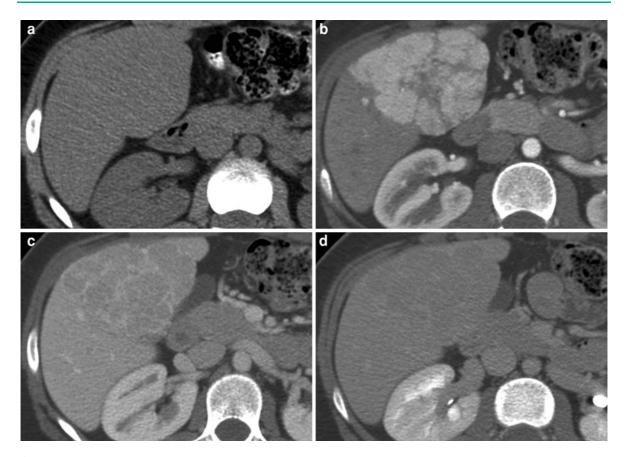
Classic focal nodular hyperplasia. a Transverse unenhanced CT image demonstrates an expanding mass in the inferior tip of the right liver lobe. Lesion shows isoattenuation relative to the surrounding liver. b Corresponding contrastenhanced CT image during hepatic arterial phase shows uniform vivid enhancement of a large hepatic lesion. Note irregular central scar and radiating septa manifesting as linear
